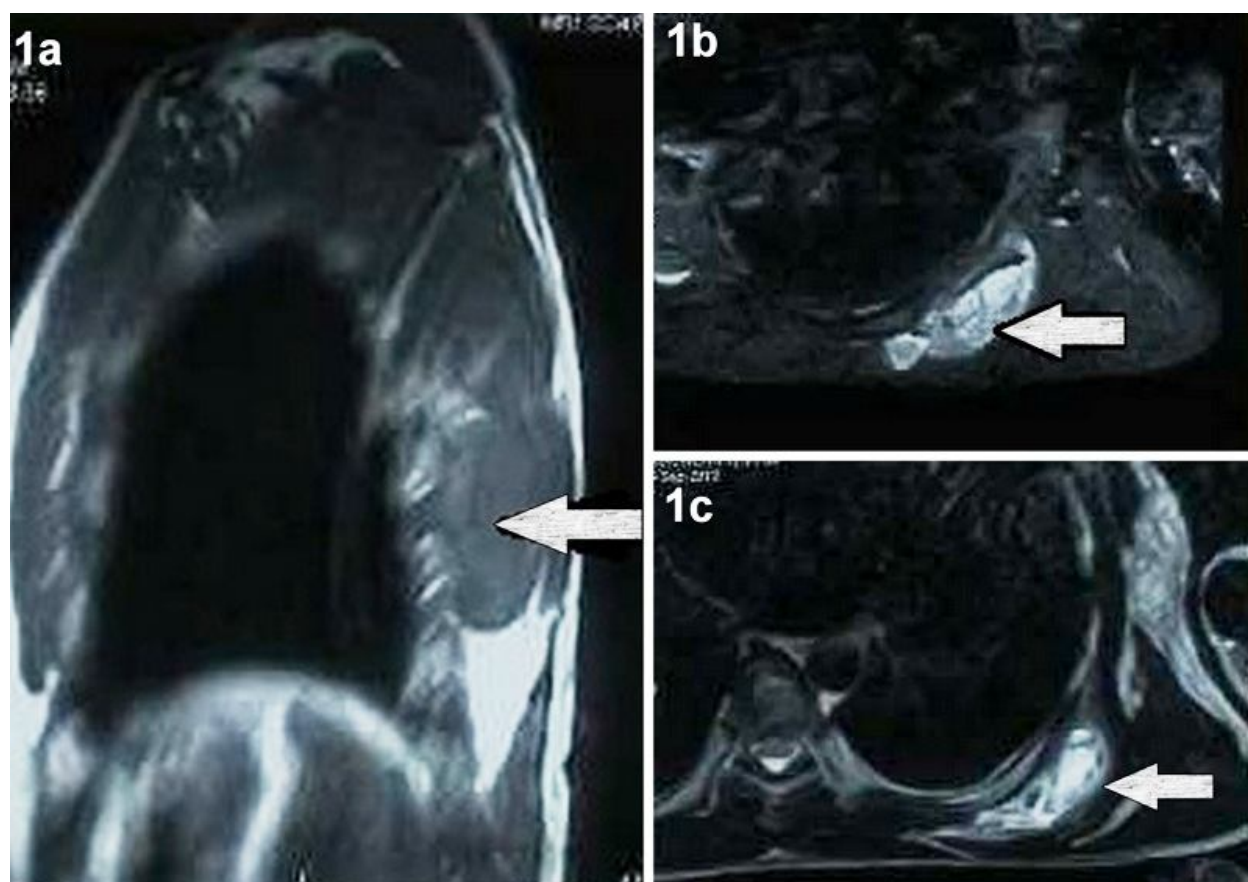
Saggital T1 (1a), axial STIR (Short T1 Inversion Recovery) (1b), axial T2 (1c) magnetic resonance imaging showing an isointense mass (marked by arrows) on T1 weighed images and hyperintense mass on T2 images.
